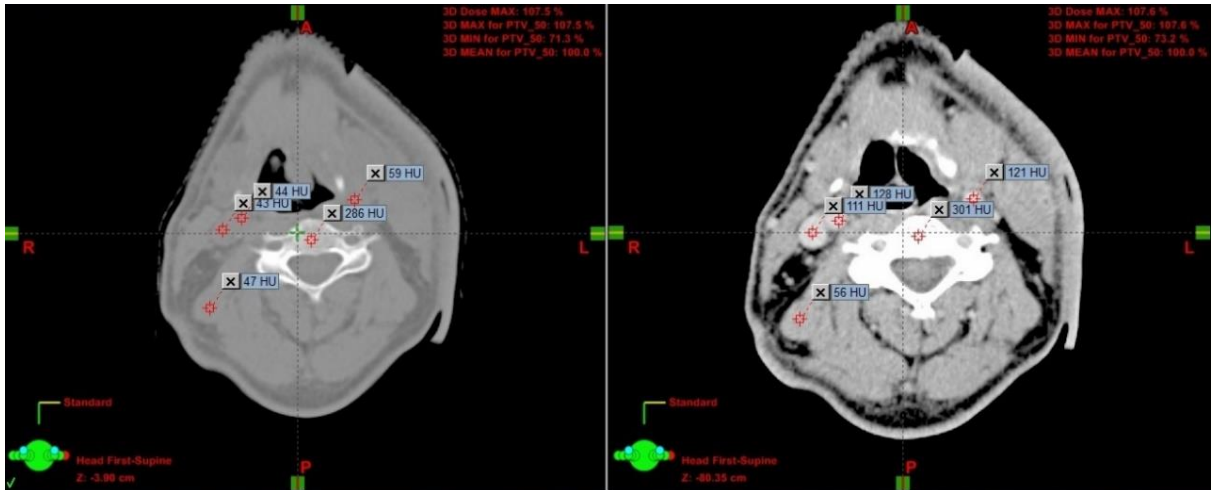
Difference of HUs between non-enchanted (left) and contrast enhanced CT scans
